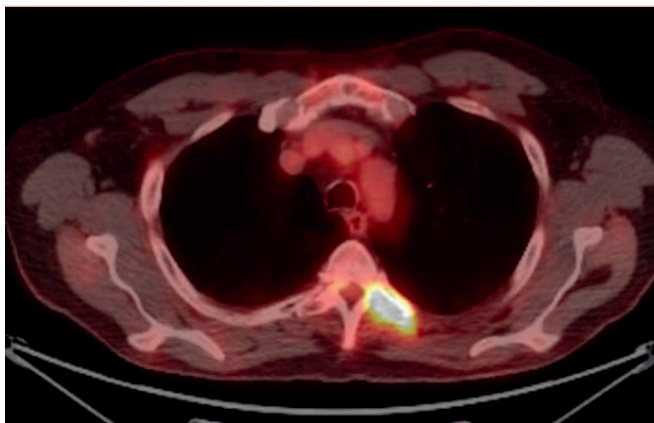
Routine imaging performed July 2020 and November 2020 demonstrating radiographic progression at T4 reflective of squamous cell metastasis. (A) PET fluorine 18 (^{18}F)-fluciclovine; (B) MRI of the spine. In the right panel, the arrow points to the progressive T4 posterior element. PET, positron emission tomography; MRI, magnetic resonance imaging.
